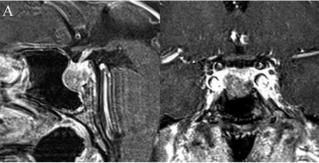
A–C: Sagittal and coronal contrast-enhanced MR images of GH-secreting macroadenomas showing isolated infrasellar extension.
